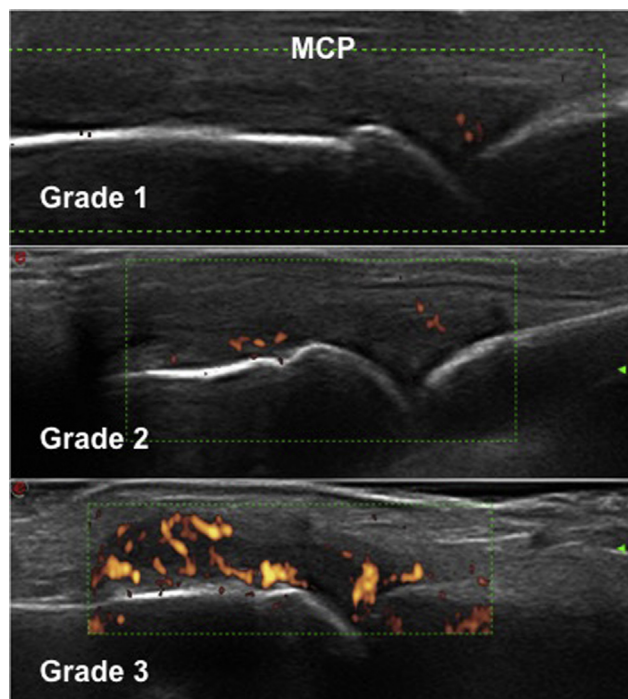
Grading of Power Doppler signal according to Szkuclarek score [6]. Grading of Power Doppler signal in joint. Grade 1: single vessel signals. Grade 2: confluent vessel signals in less than 50% of the synovial area. Grade 3: vessel signals in more than 50% of the synovial aera.
